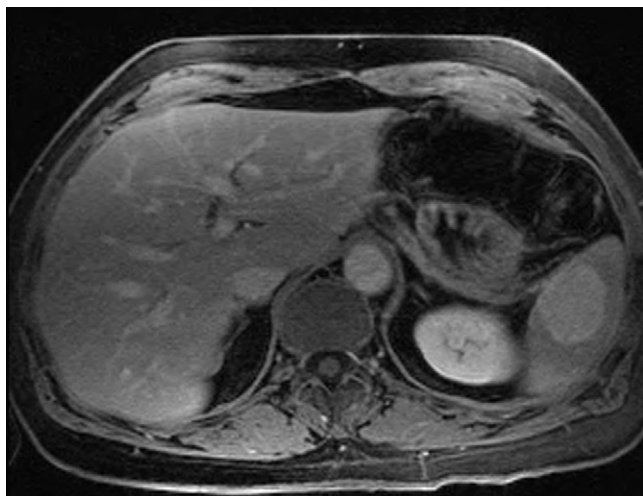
Magnetic resonance imaging (MRI) showing the lesion in the lower spleen.
